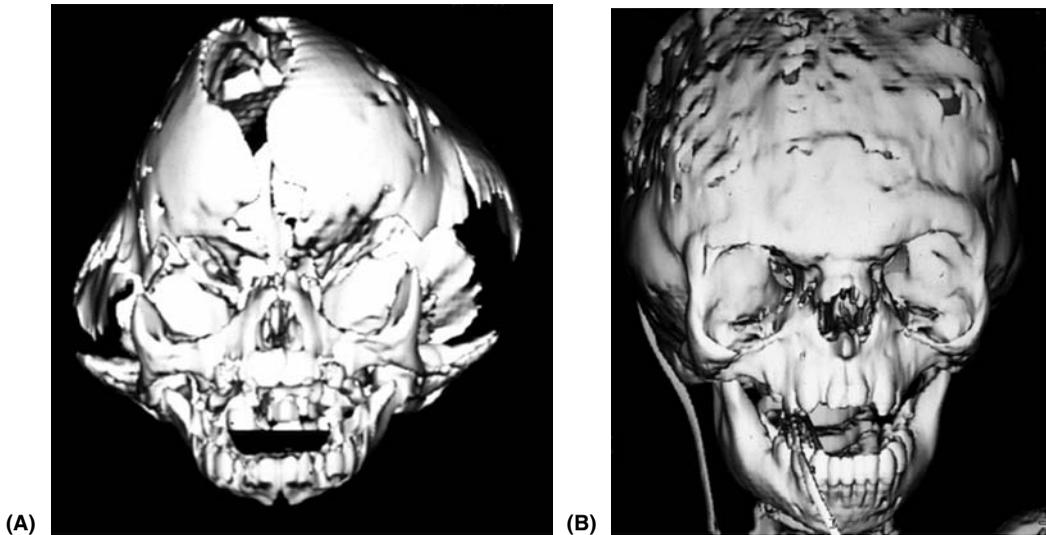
Three-dimensional computed tomography scan of a child with Kleeblattschädel deformity. (A) Preoperative view and (B) postoperative view.
